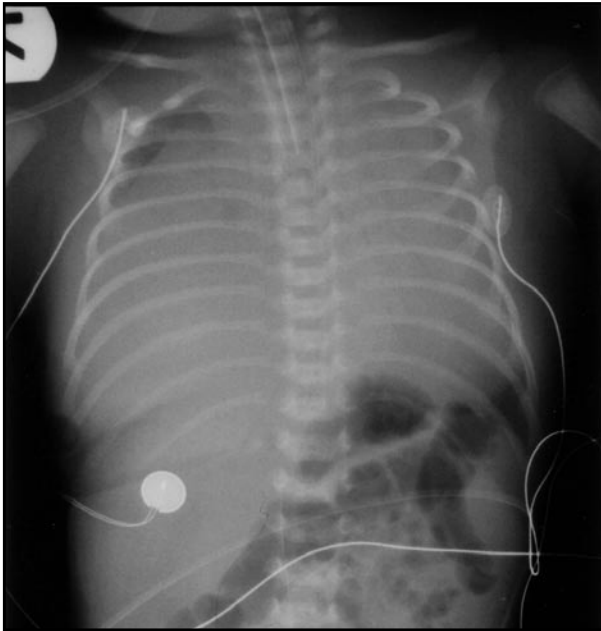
Initial chest X-ray showing bilateral pleural effusion
